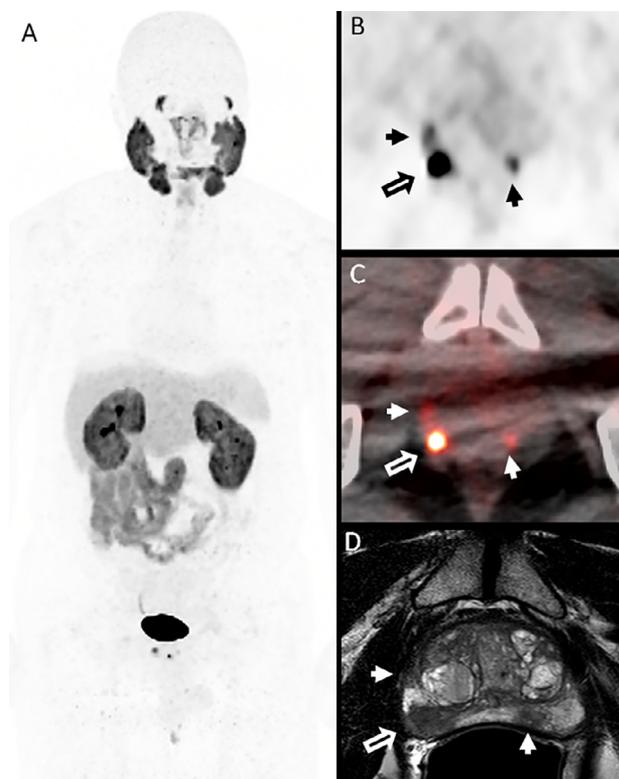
^{18}F -DCFPyL PET/CT in a patient with high-risk primary prostate cancer. Maximal intensity projection (A), axial ^{18}F -DCFPyL PET (B), and axial-fused PET/CT (C) images demonstrate a dominant DCFPyL-avid focus at the right apical-mid peripheral zone (PZ) (open arrow), and additional smaller abnormal foci of uptake at the right anterior mid PZ, and left mid PZ (small arrows), all concordant with the T2W MRI findings (D).
